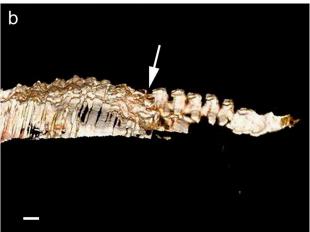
Three-dimensional computed tomography (a) dorsoventral and (b) lateral images of the caudal aspect of the vertebral column of a 2-month-old chicken, showing the space between the synsacrum and the first free coccygeal vertebra (white arrow) (bar = 1 cm).
